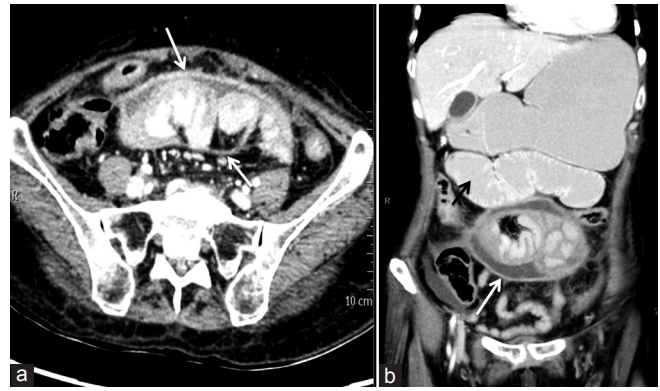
Abdominal cocoon formation in 30-year-old male with previous abdominal surgery. (a) Axial contrast-enhanced computed tomography scan showing clustering of bowel loops with fibrotic enhancing membrane (arrows). (b) Coronal reformatted image showing the encapsulation of ileal loops in a membrane (white arrow) with fluid collection within the sac and dilatation of proximal jejunum (black arrow)
